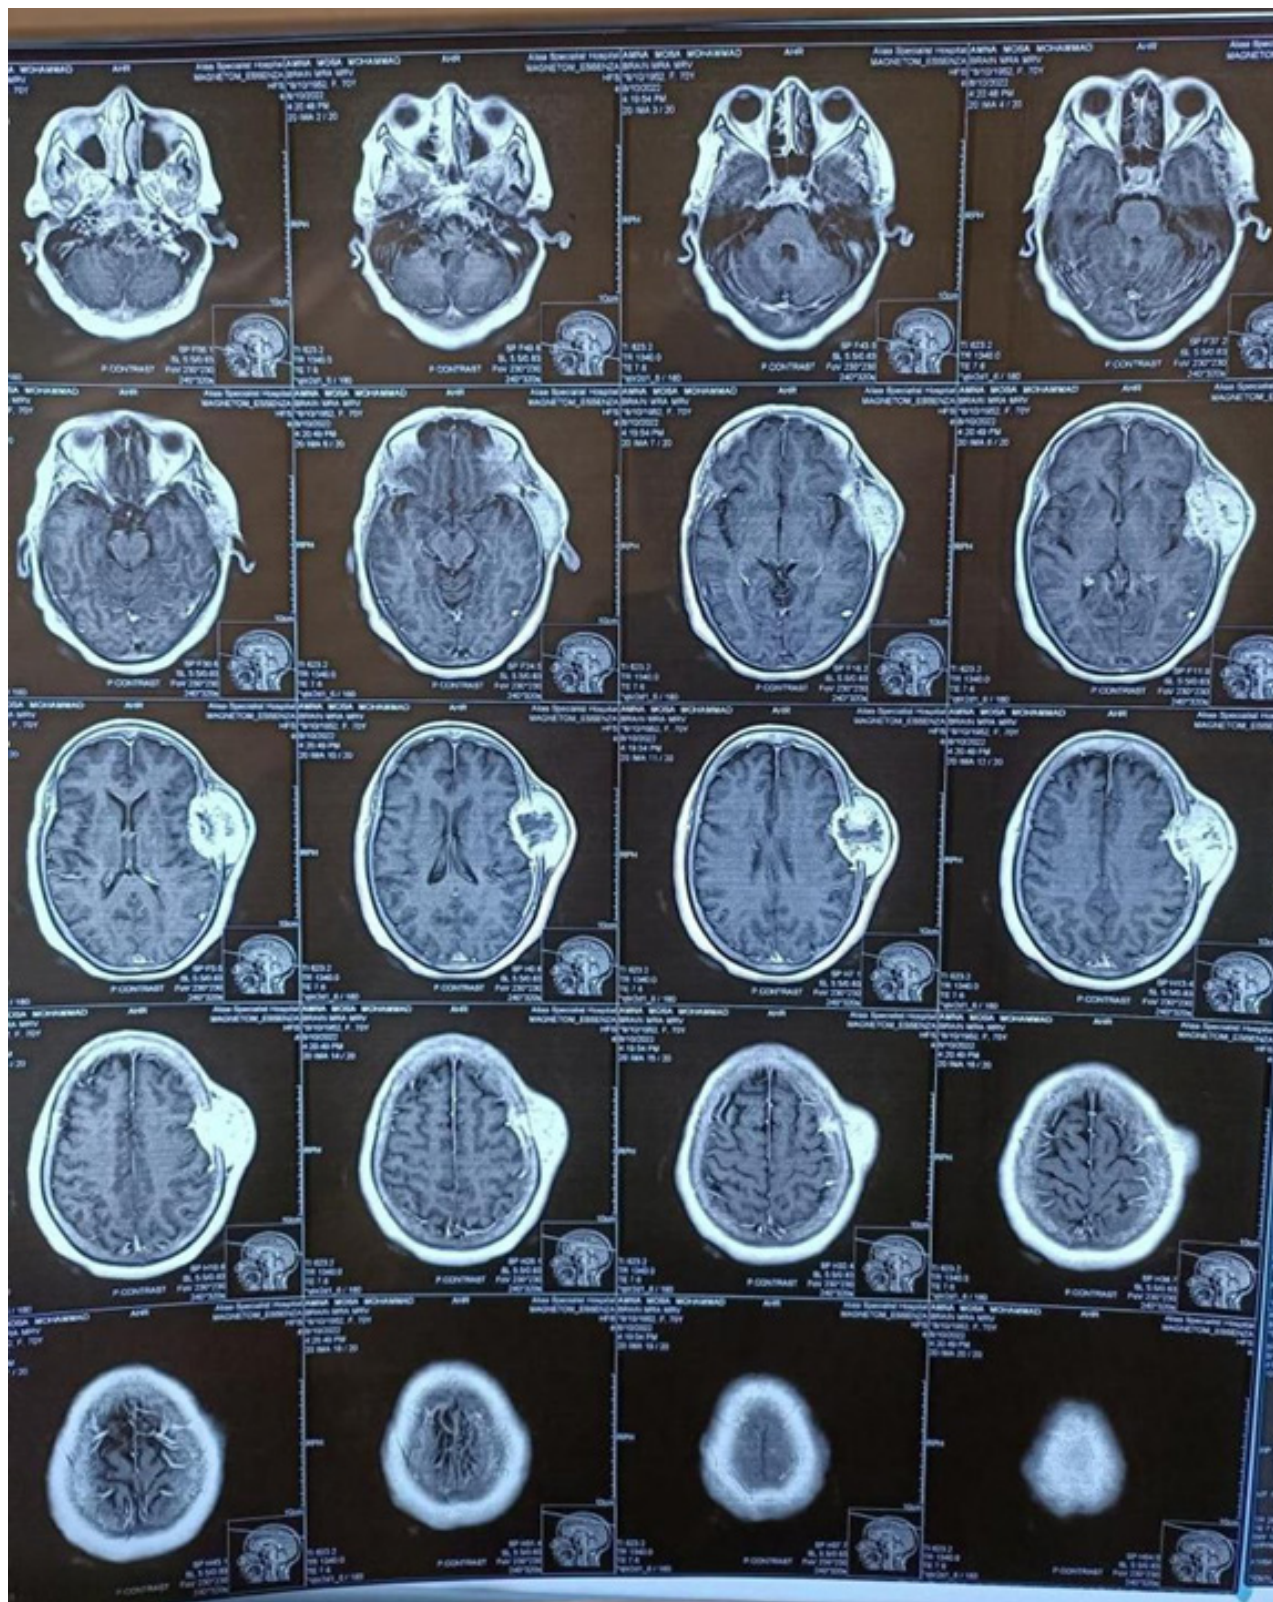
MRI scan with contrast, axial cut, T1 sequence shows the intense enhancement with central hypo intensity noticed.
